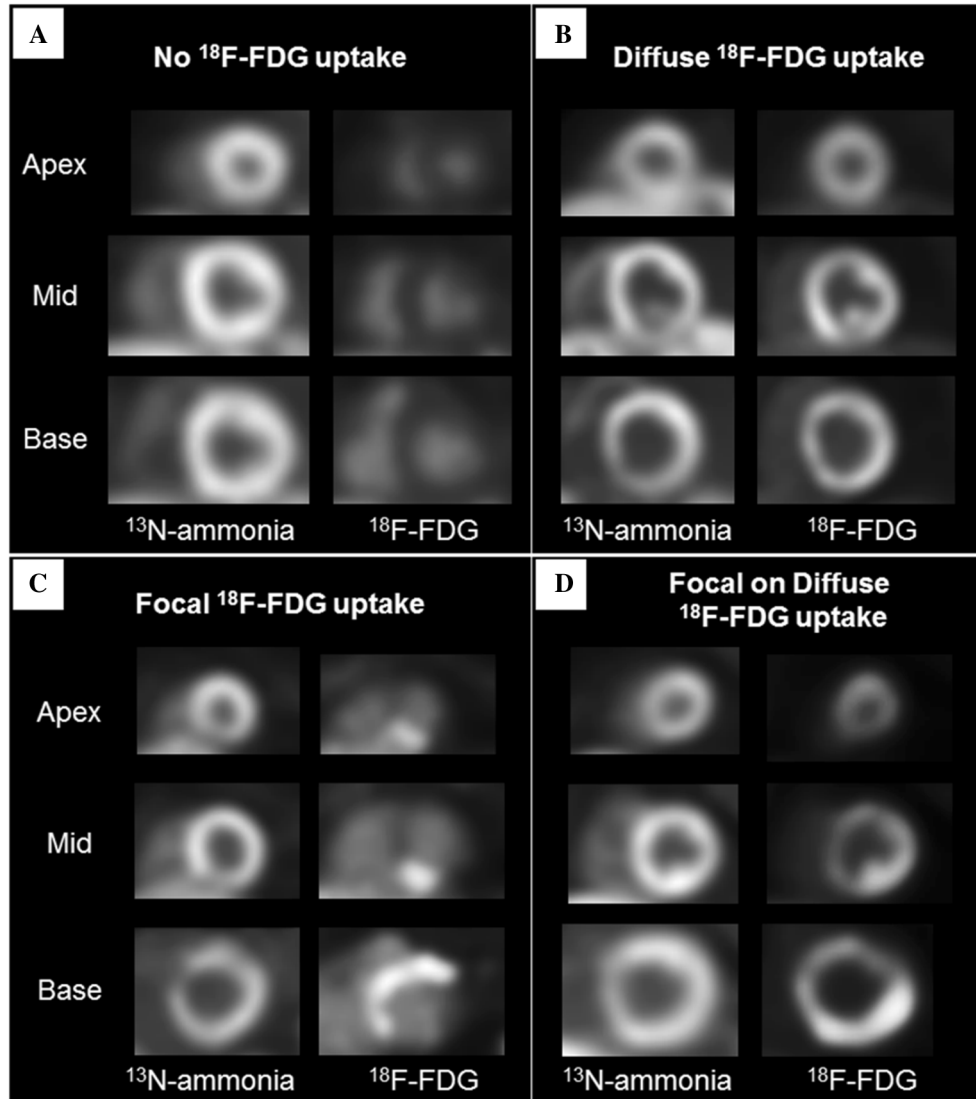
Patterns of myocardial ^{18}F -FDG uptake on cardiac PET. Patterns of myocardial 18-fluorodeoxyglucose (FDG) uptake were interpreted per established guidelines as follows: (A) No ^{18}F -FDG uptake, (B) diffuse myocardial ^{18}F -FDG uptake, (C) focal ^{18}F -FDG uptake, and (D) focal on diffuse ^{18}F -FDG. Patients presented in panels (A) and (C) were considered to have appropriate suppression of physiologic myocardial ^{18}F -FDG uptake while (B) had suboptimal suppression of myocardial ^{18}F -FDG uptake. Patients in panel (D) had either appropriate or suboptimal suppression of myocardial ^{18}F -FDG uptake based on discretion of the cardiac imager (see Methods).
